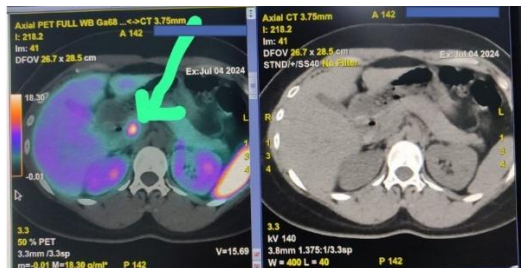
a  $^{68}\text{Ga}$ -DOTATATE PET/CT shows suggestive a insulinoma at head of pancreas
